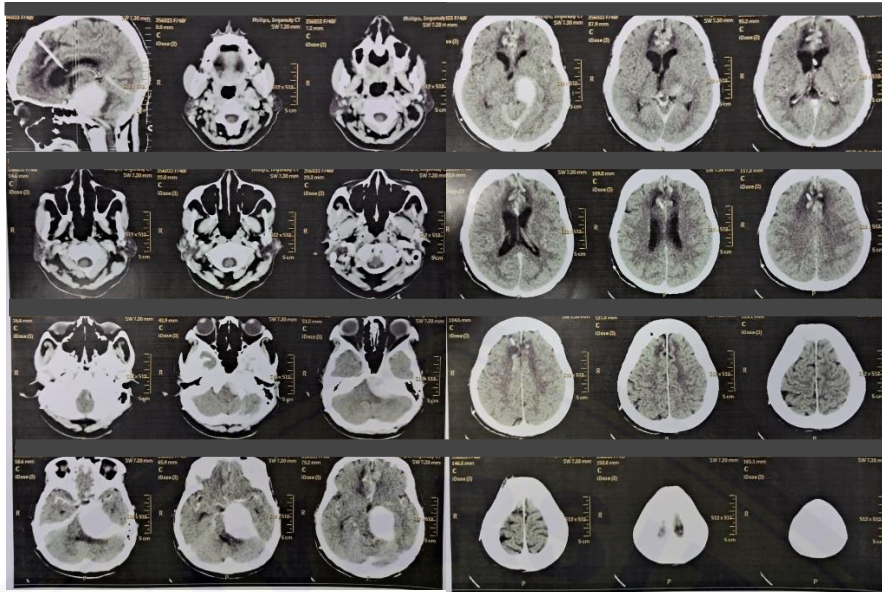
Preoperative Head CT-scan with Contrast
